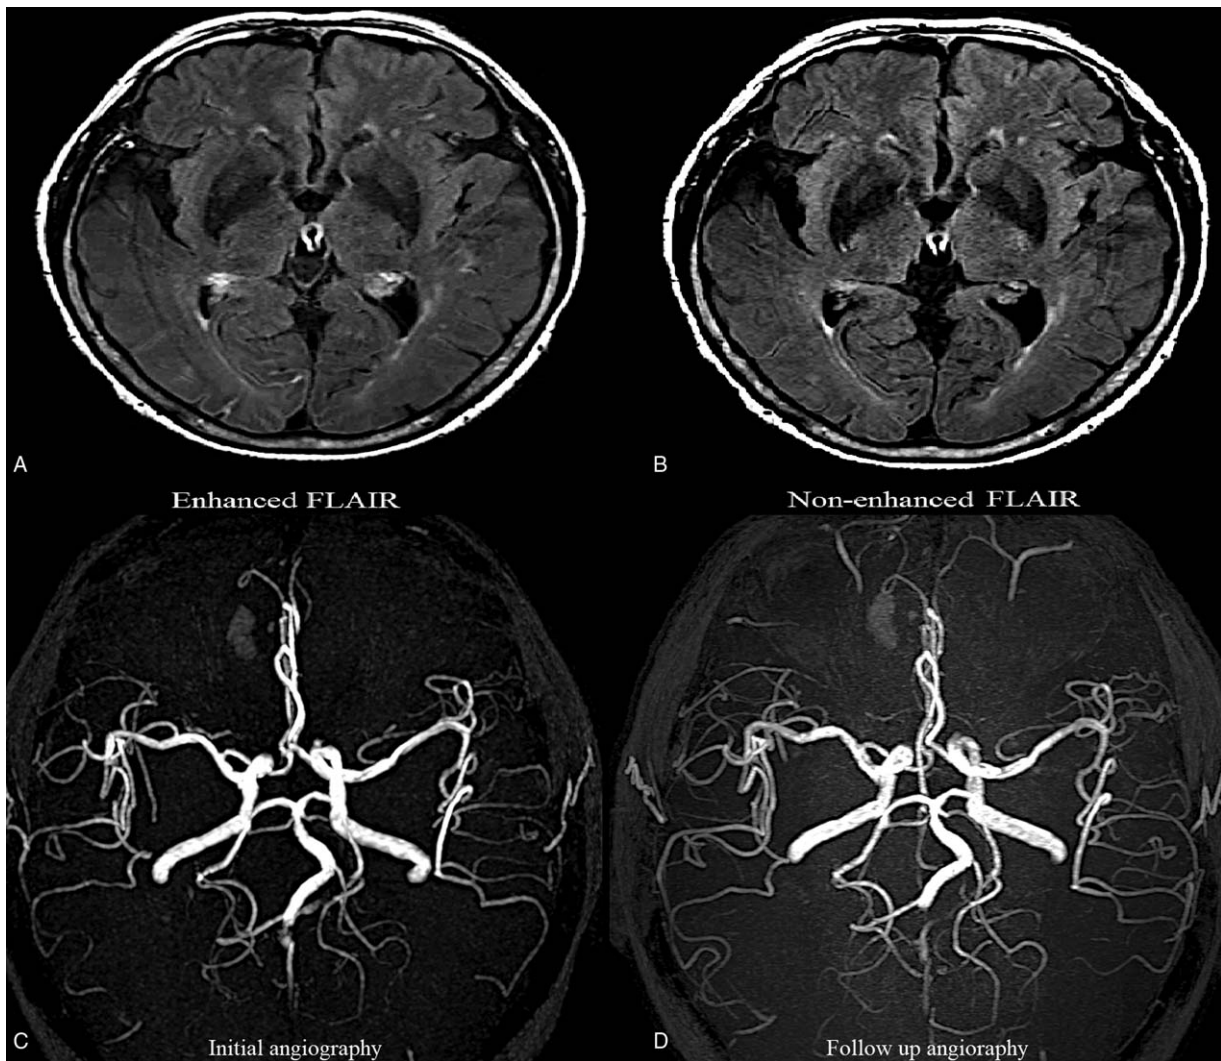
HARM sign in a patient with RCVS. The enhanced FLAIR image (A) showed the cortical HARM sign (arrow) in the bilateral temporal-occipital lobes compared to the non-enhanced FLAIR (B). A 67-year-old female visited as a result of a transient language problem (impairment of comprehension) and right arm weakness with preceding thunderclap headache 2 days ago. Initial MR angiography (C) showed multifocal stenosis through distal branches of the left middle cerebral artery and posterior cerebral artery that were improved in the follow-up angiography (D).
